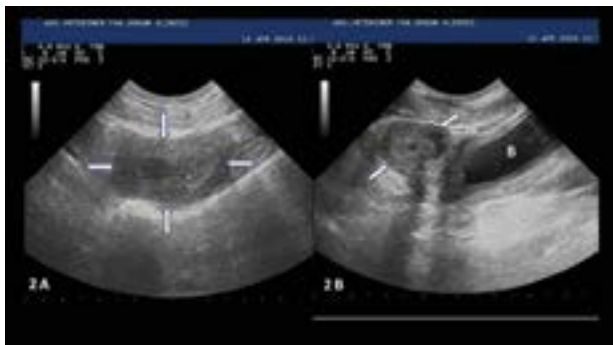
2A Ultrasonographic image of abdominal mass in Case 2, 2B: Ultrasonographic image of pelvic mass adjacent to bladder in Case 2
